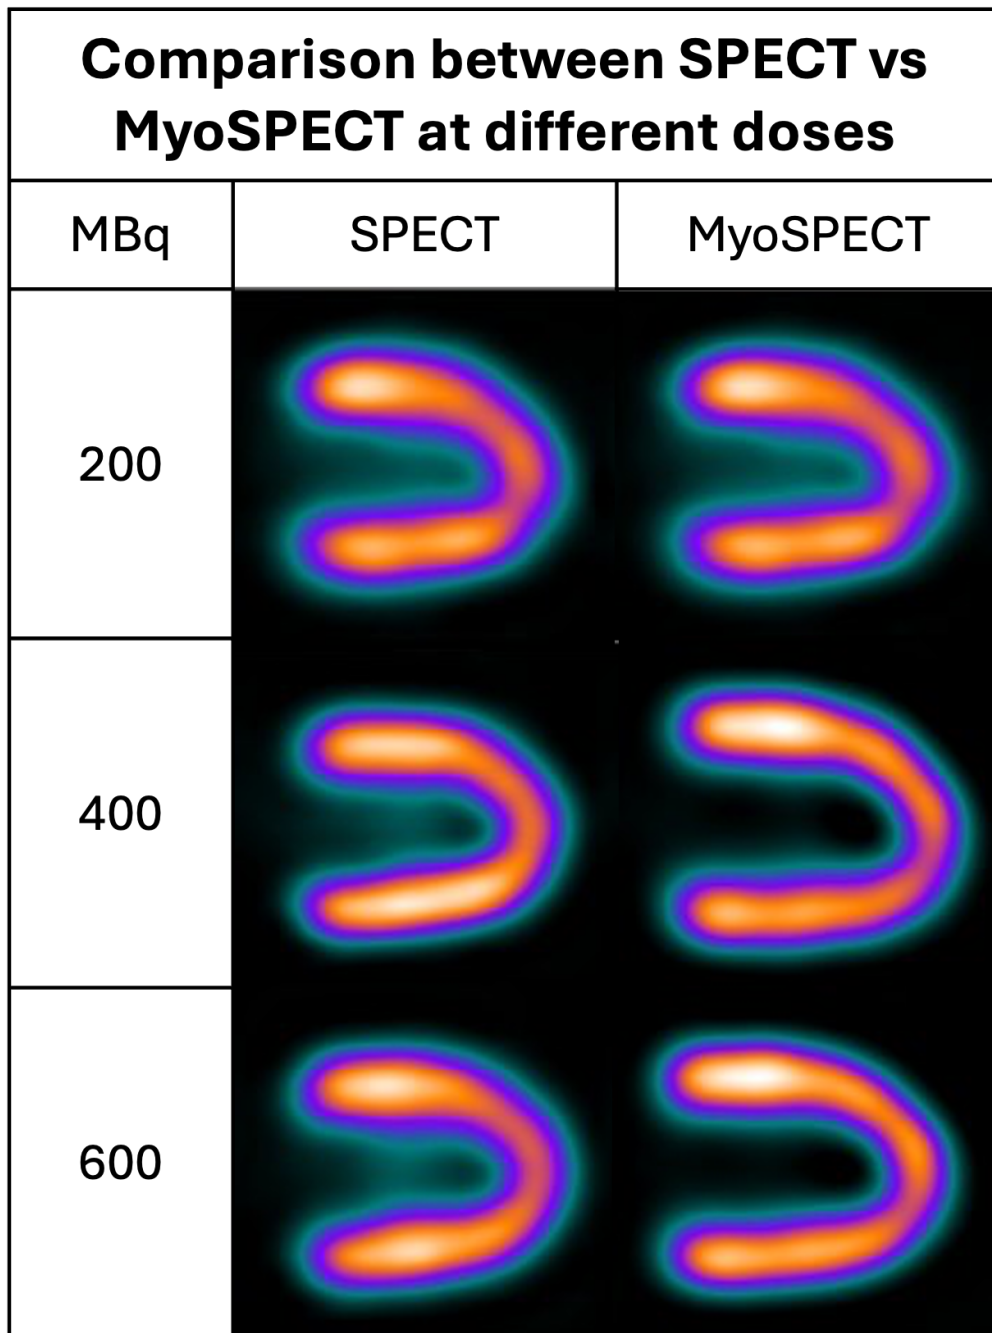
Comparison of SPECT and MyoSPECT through the VLA view
